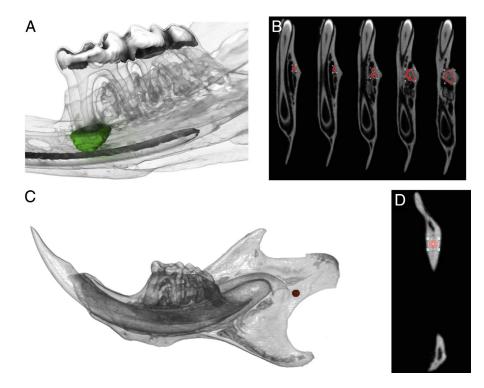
Images of a mandibular first molar with pulp exposure obtained by micro–computed tomographic imaging. (*A*) Three-dimensional rendered image. The *green* area represents a periapical volume of interest consistent with a periapical lesion. (*B*) Slices in the axial plane. The *red* areas represent examples of the region of interest used to calculate periapical lesion volume. Every fifth slice from the first slice starting at the bottom of the tooth socket is shown (slices #1, 6, 11, 16, and 20). (*C*) Three-dimensional rendered image. The *red* area represents a sphere in the mandibular ramus where bone density was measured. (*D*) A slice in the coronal plane. The *red* area represents an example of a region of interest used to calculate bone density.
